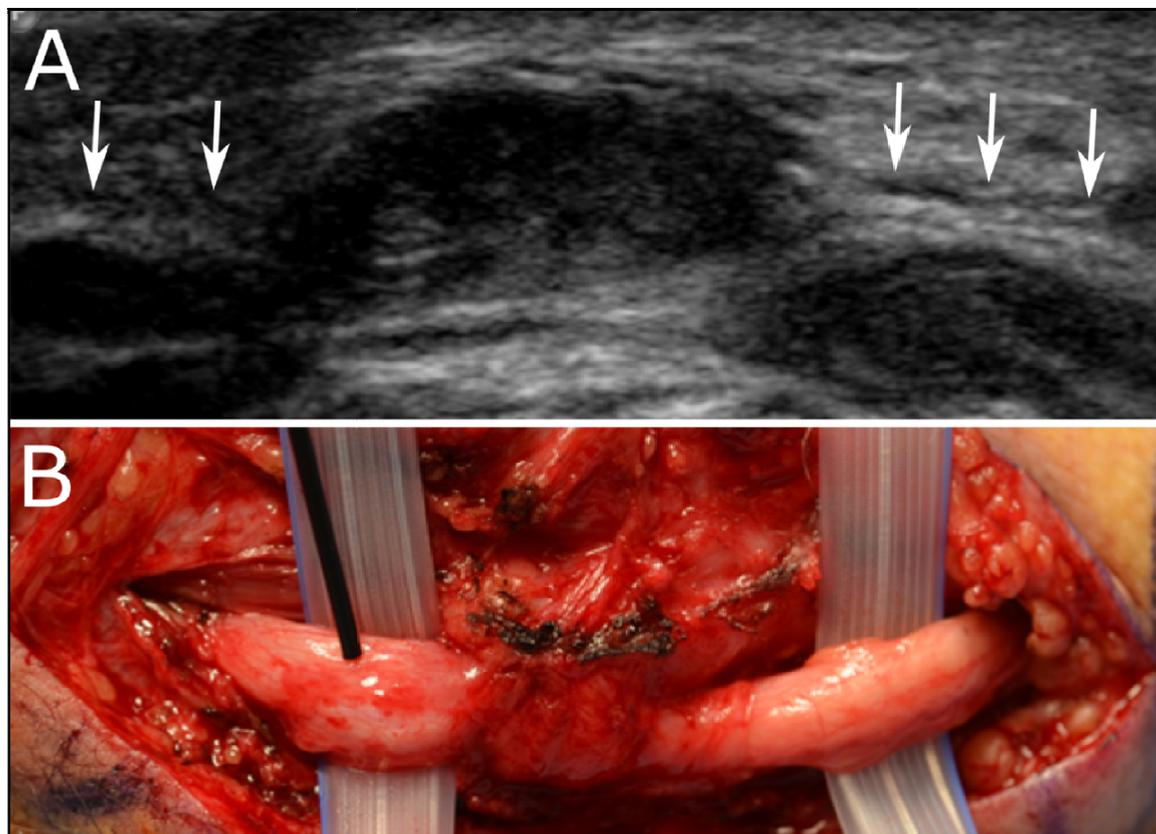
Laceration of the ulnar nerve. Longitudinal ultrasound at the site of a laceration (A) demonstrates a large hypoechoic focus along the course of the ulnar nerve with complete loss of fibrillar structure. Arrows delineate the normal segments of the ulnar nerve. Intraoperative image (B) demonstrates discontinuity of the nerve corresponding to the hypoechoic focus.
